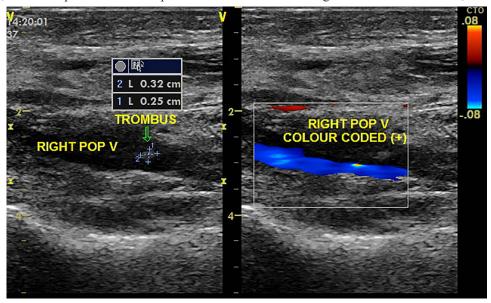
DUS at admission showed right popliteal vein thrombus. DUS: duplex ultrasonography.
